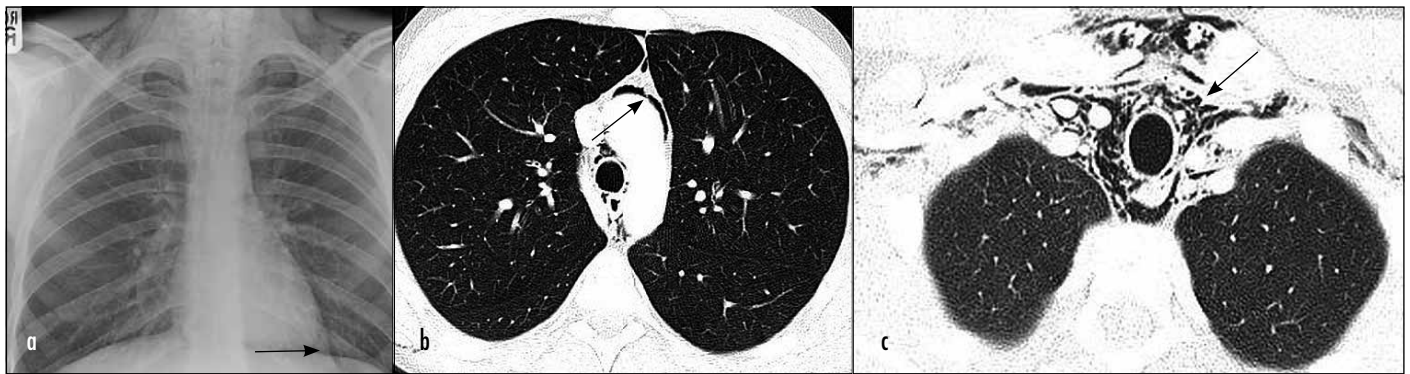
a. A chest X-ray in a patient presenting with excessive vomiting, dyspnoea and palpable subcutaneous emphysema in the right supraclavicular region. The limitations of a chest X-ray are demonstrated as the pneumomediastinum is subtle. However, given the clinical history, the presence of a thin rim of air around the cardiac apex (arrow) and bilateral supraclavicular subcutaneous emphysema, it raises a strong index of suspicion for an oesophageal or tracheal perforation. Thoracic computed tomography of the same patient demonstrating (b) mediastinal air (arrow) and (c) extensive supraclavicular air (arrow). The computed tomography confirmed a proximal oesophageal perforation.
